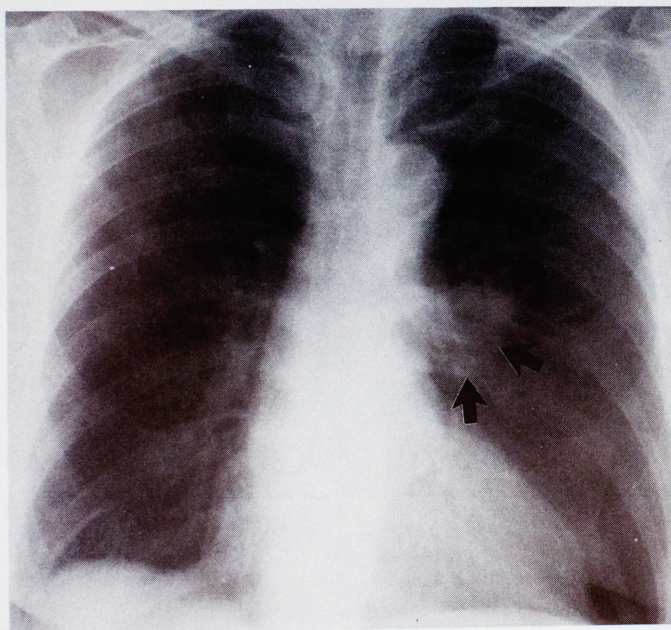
Posteroanterior chest x-ray film of a patient with carcinosarcoma of the lung shows a well-margined mass (arrows) in the medial aspect of the left upper lobe. Postbiopsy pneumothorax is also seen (left).
